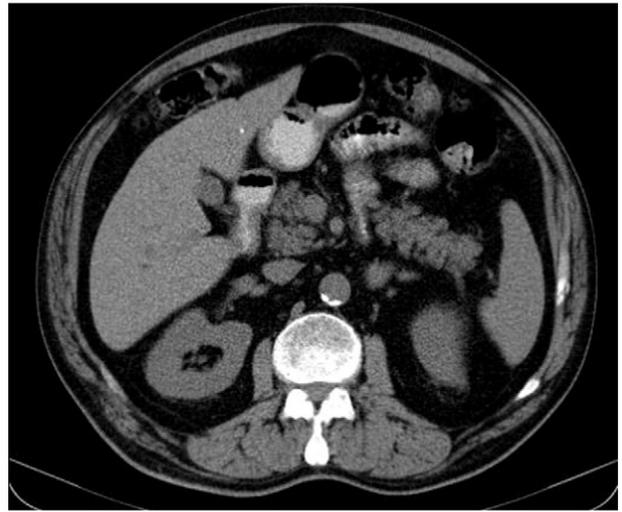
A CT scan showed that the transverse colon was interposed between the liver and diaphragm.
